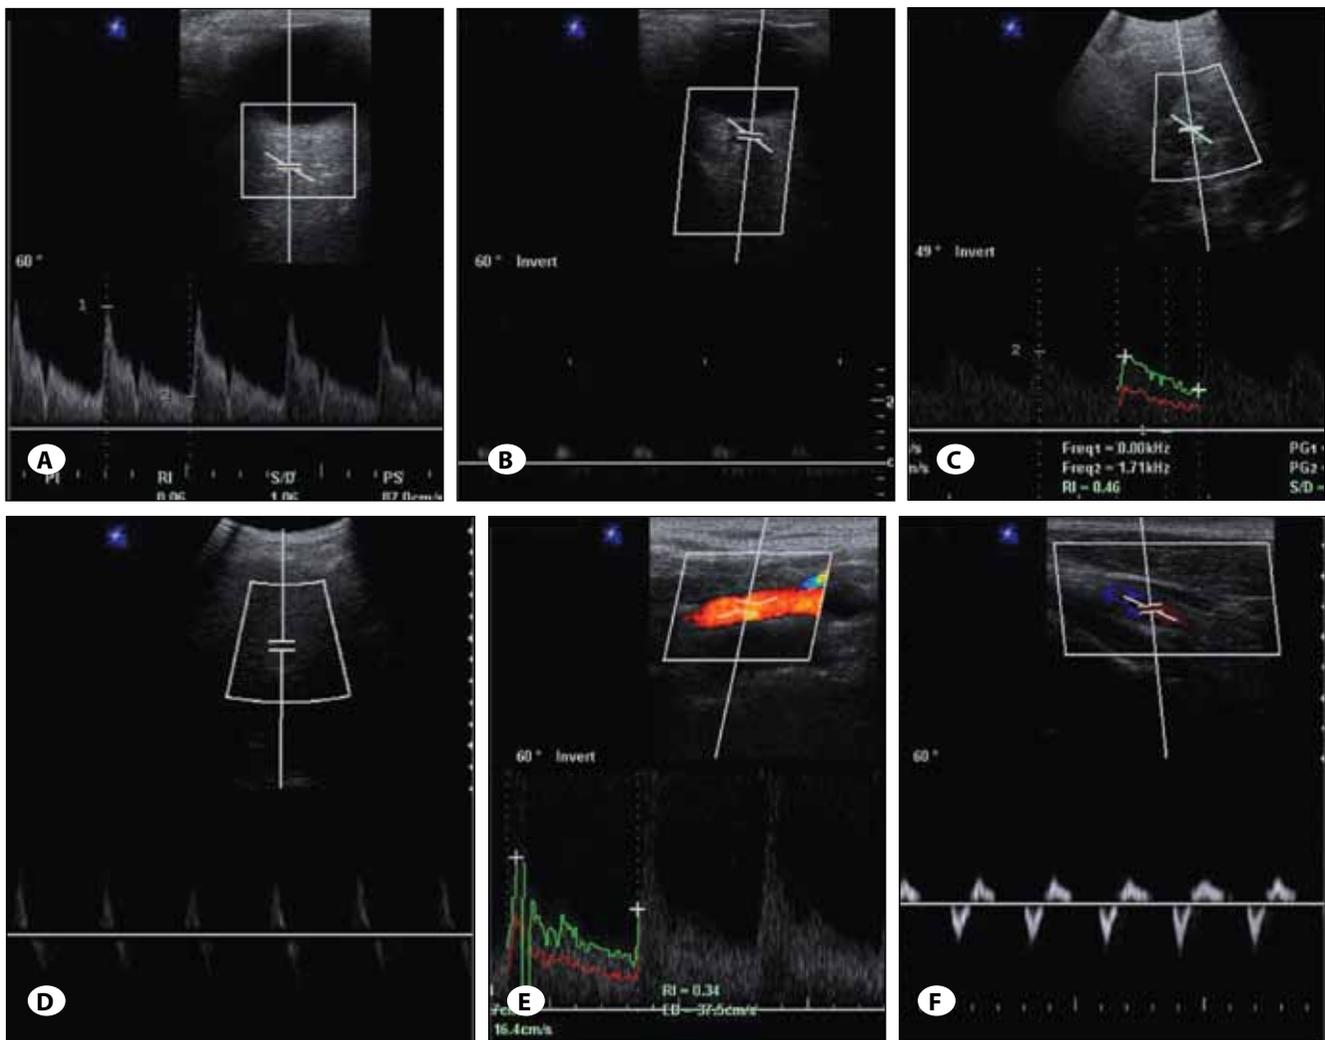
The control Doppler ultrasound (DUS) images of a 49-year old male volunteer and DUS images of the patient in figure 1 who had postoperative brain death following tumor surgery. The A) orbital, C) transcranial, and E) internal carotid DUS examinations of the control patient show arterial flow with low resistance (RI values: 0.06, 0.46, 0.34; respectively). In the patient with a diagnosis of brain death, B) cessation of flow ($RI^{ODUS}=1$) during diastole on orbital DUS examination, and D) presence of reverse flow on transcranial and F) internal carotid DUS examinations are shown (RI^{TDUS} and $RI^{CDUS}=1$). The flow pattern in Figure 3B, Figure 3D, and Figure 3F are compatible with brain death ($RI \geq 1$).
